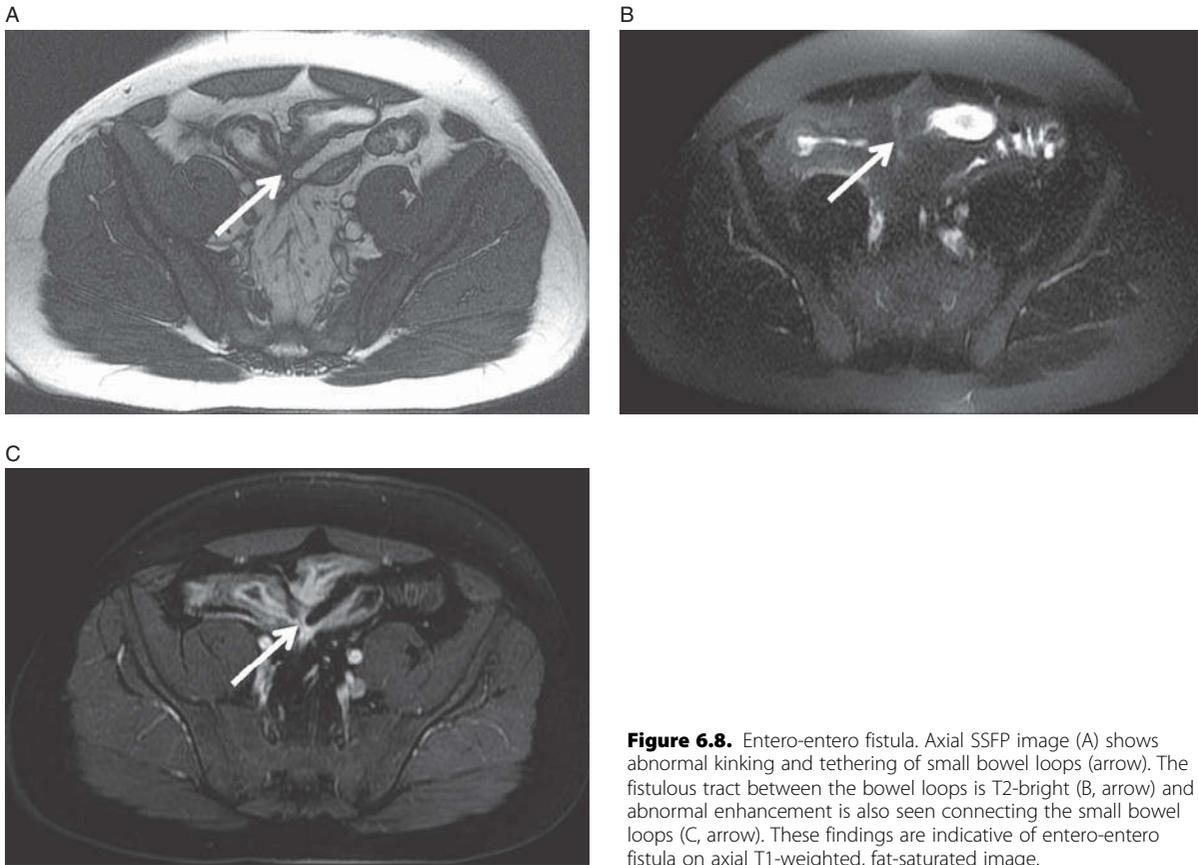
Entero-entero fistula. Axial SSFP image (A) shows abnormal kinking and tethering of small bowel loops (arrow). The fistulous tract between the bowel loops is T2-bright (B, arrow) and abnormal enhancement is also seen connecting the small bowel loops (C, arrow). These findings are indicative of entero-entero fistula on axial T1-weighted, fat-saturated image.
